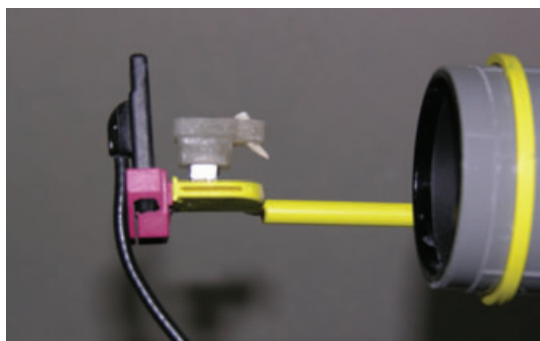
A modified film holder to obtain standard radiographic images.
